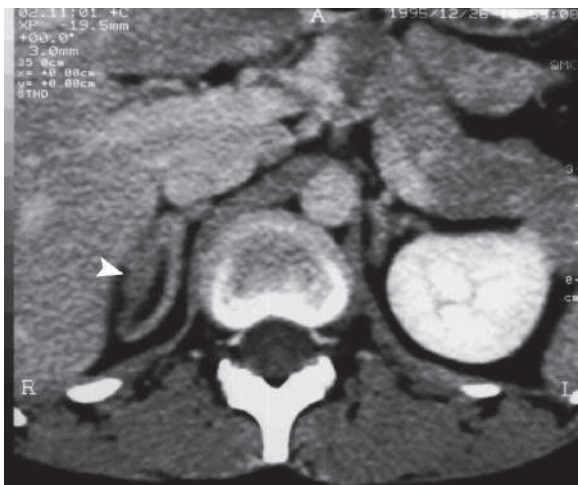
Axial postcontrast CT image of a patient with adrenal hyperplasia shows enlargement of the lateral limb of the right adrenal gland (*arrowhead*)
